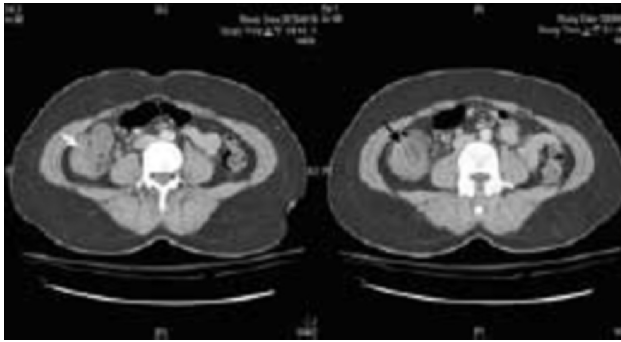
Computed tomography shows intussusception with short segment of terminal ileum into proximal ascending colon (white arrow) and layers of the bowel within the bowel (target sign, black arrow) in cross section.
